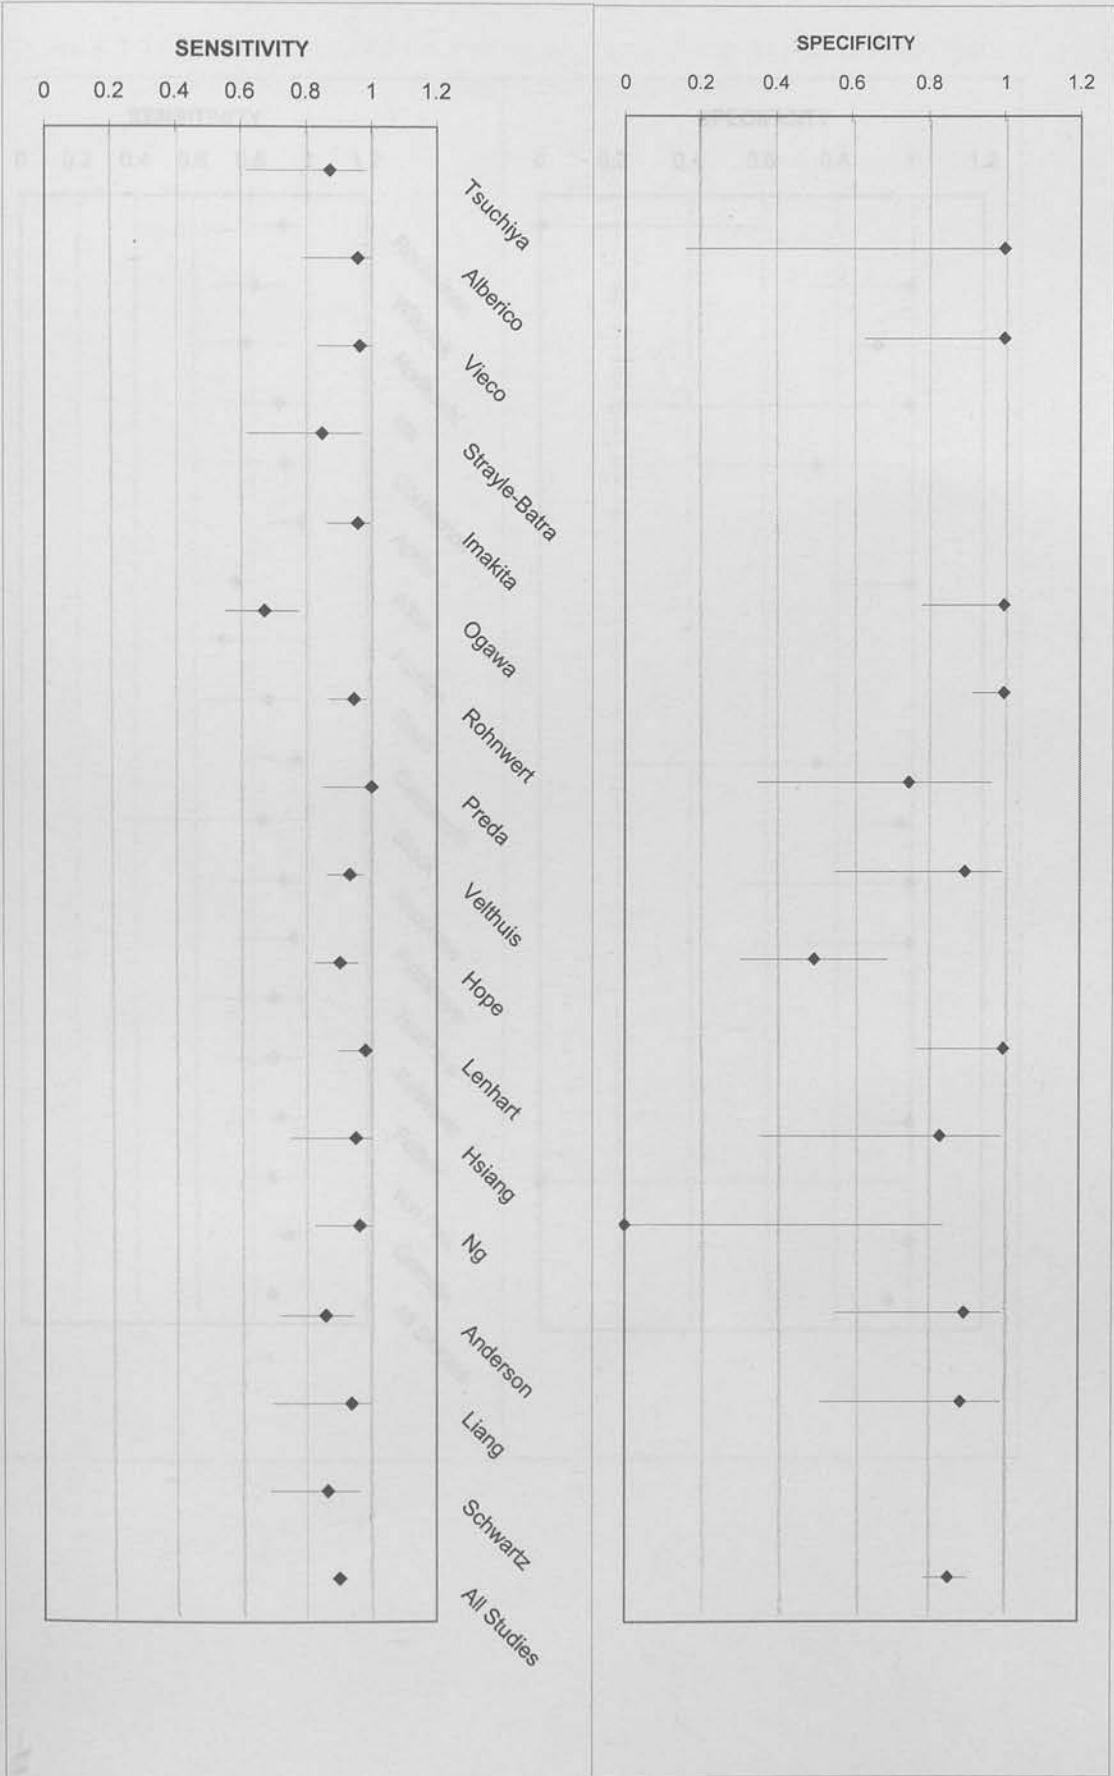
Forrest plots of sensitivity and specificity per aneurysm for CTA studies included in systematic review
